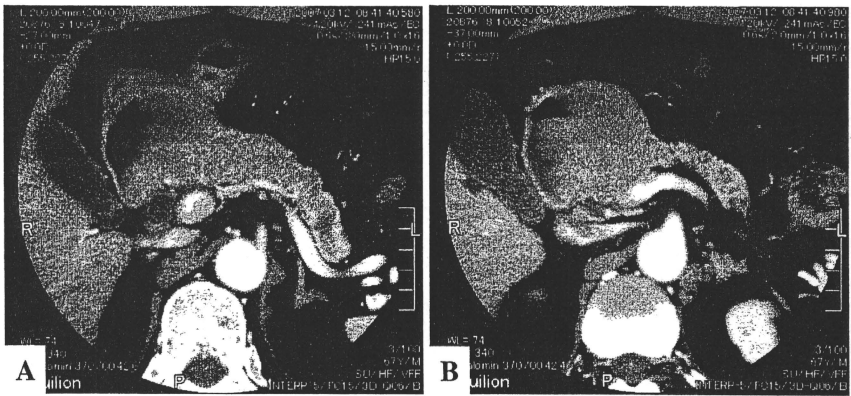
Enhanced computed tomography detected a low density, relatively clear-margined tumor with maximum diameter of 10 cm in the pancreatic head. The tumor totally occupied the main pancreatic duct from the head to the tail of the pancreas. The duodenum was clearly invaded by tumor (A). The tumor was close to the portal vein (B).
